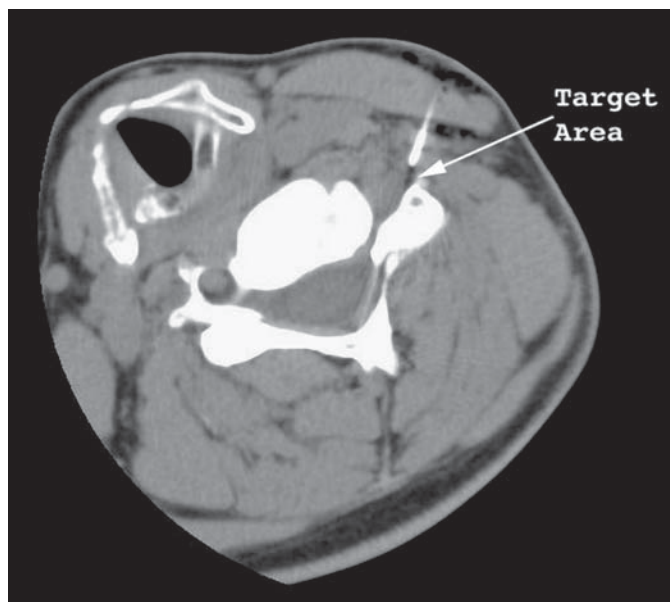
Cervical SNRB using CT guidance.
